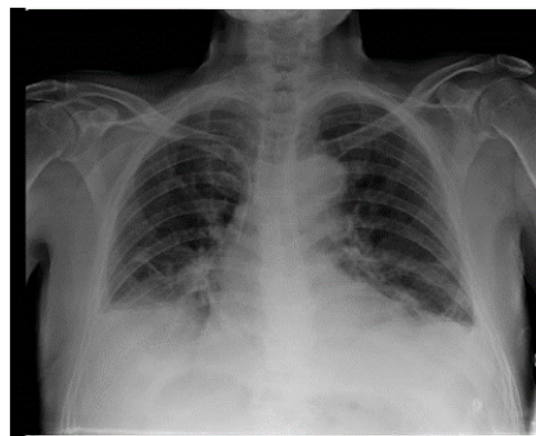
Chest x-ray at admission.
